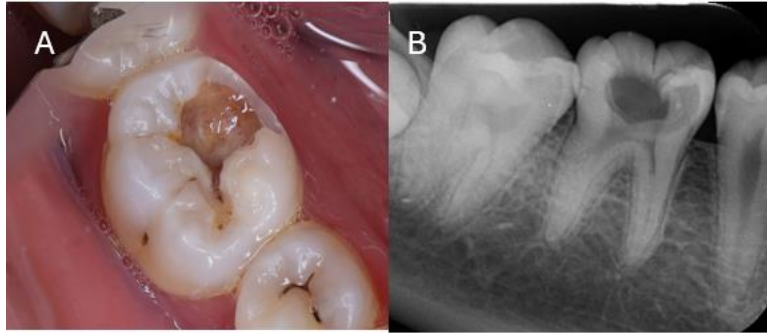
(A) Intraoral preoperative photograph of tooth 46 showing deep class I carious lesion. (B) Preoperative periapical radiograph showing deep carious lesion involving the pulp with widening of periodontal space apically
